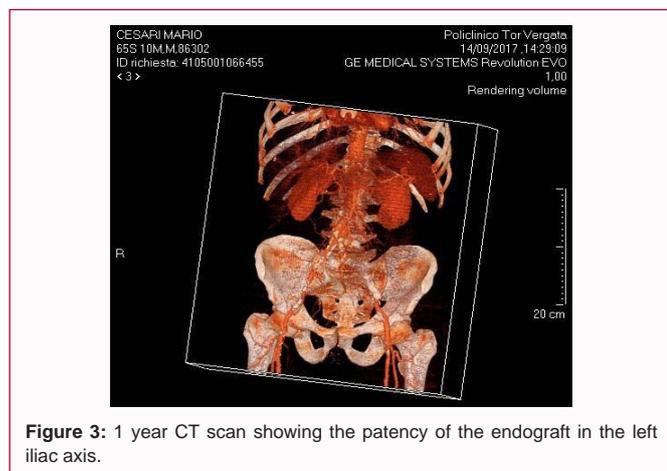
1 year CT scan showing the patency of the endograft in the left iliac axis.
